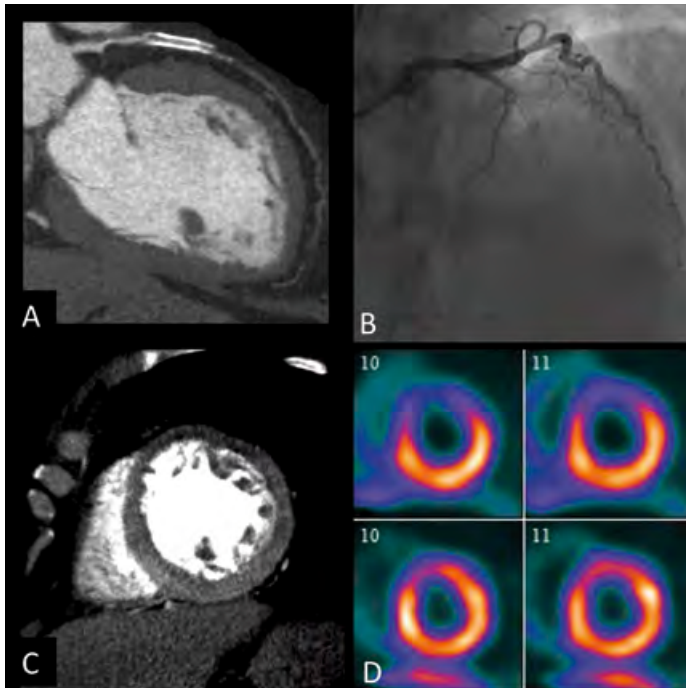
An example case of the four study imaging components. Panel A depicts a CTA image with an occlusion of the left anterior descending artery. Panel B depicts an ICA image confirming the occluded left anterior descending artery. Panel C is a stress CTP short-axis reconstruction with a defect visible in the anterior wall. In this patient, defects were seen on CTP in the basal anterior (severe), distal anterior (severe), distal anteroseptal (moderate), and apical (moderate) walls. Distal anterior and apical defects had fixed components. Panel D: SPECT MPI images with perfusion defects in the distal anterior (severe), distal anteroseptal (severe, fixed), and apical (severe) walls.
